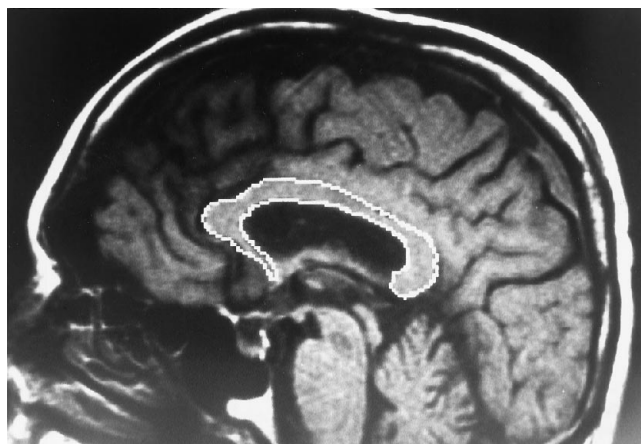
Midsagittal T1-weighted (600/20) image of a healthy subject. The border of the corpus callosum has been outlined by a neuroradiologist who used a trackball and the MR computer to create a region of interest. From this region of interest, the MR computer calculated the area enclosed to provide a measure of the callosal area.
